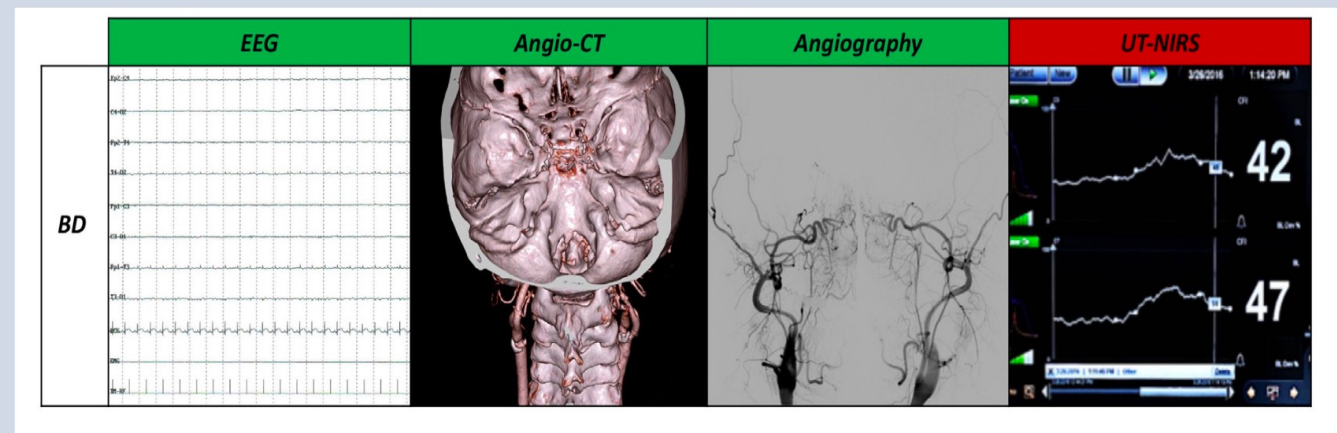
Instrumental findings in brain-dead patients. From left to right: EEG recording (showing isoelectric signal) and two images demonstrating absent intracranial progression of arterial blood flow, respectively, using angio-CT scan or angiography. These two images come from separate patients (because multiple confirmatory exams directly concerning cerebral blood flow are not indicated in the same subject). All these findings are consistent with absent cerebral blood flow. The last panel shows the ultrasound-tagged near-infrared spectroscopy (UT-NIRS) recording, which seems to indicate persistent cerebral flow index in both hemispheres, in contradiction with the other confirmatory tests. BD, brain dead.
